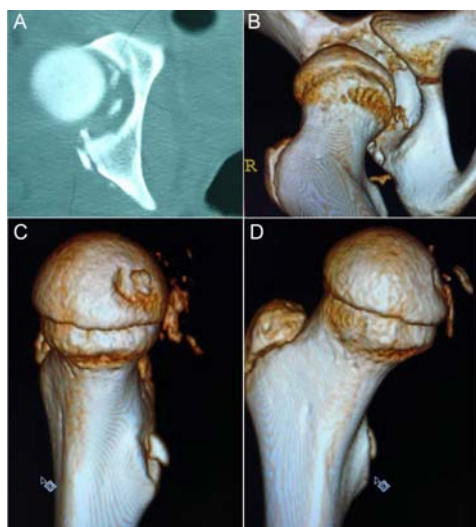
(A-D) Preoperative 3D-CT scans reveals multiple loose bodies entrapped in the joint and joint space widening
